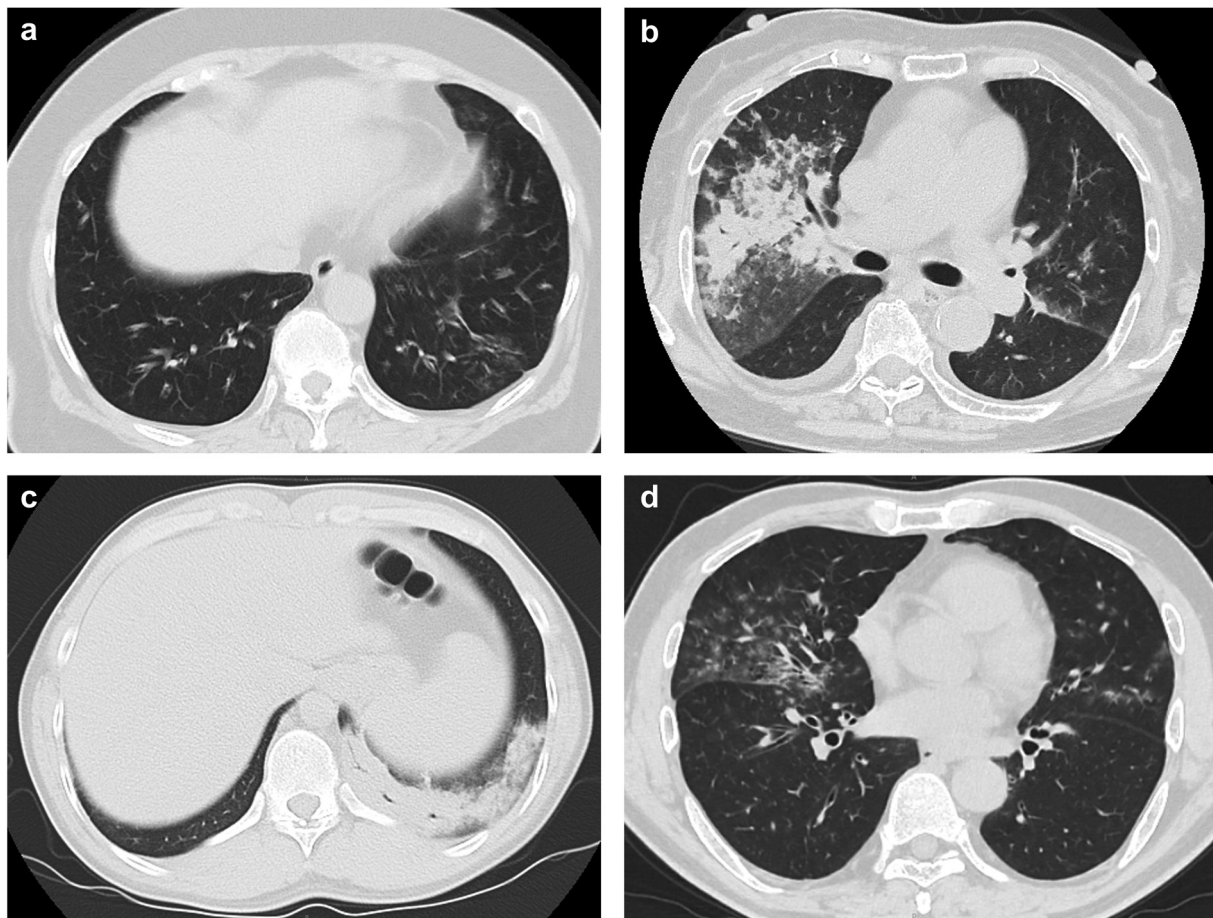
Representative chest CT images in community-acquired hMPV pneumonia. a: Patient no. 1. b: Patient no. 2. c: Patient no. 3. d: Patient no. 4. a, d: Lobular opacities with bronchial wall thickening. b, c: Dense consolidation.
